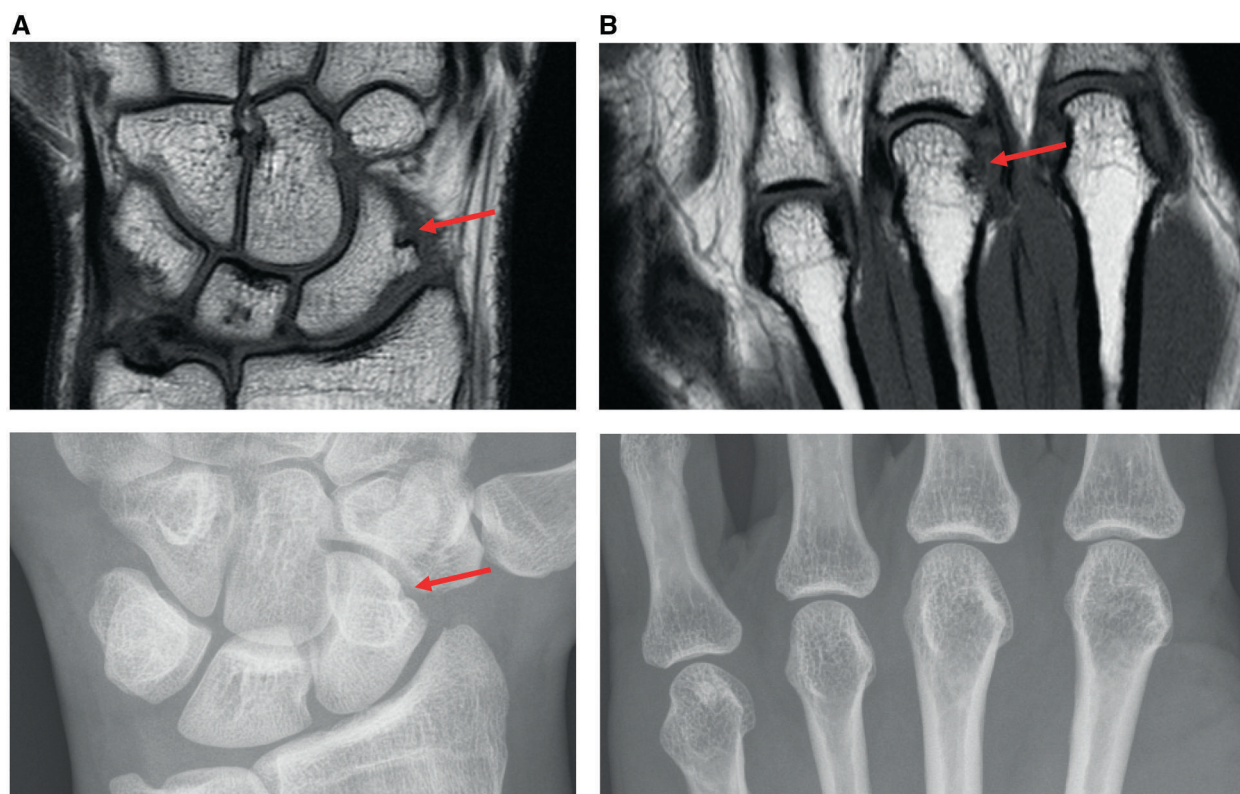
Two examples of an MRI-detected erosion with (A) a radiograph of the same location at the same time point with a radiographic erosion and (B) without a radiographic erosion. Two examples of CSA patients with an MRI erosion: the MRI and radiographs are performed at the same moment in time. (A) T1-weighted MRI of the left hand showing erosion of the scaphoid bone, with a minor cortex break at that location on the radiograph. (B) T1-weighted MRI of the left hand showing erosion of the third proximal metacarpophalangeal bone, with a normal radiograph from the same hand
